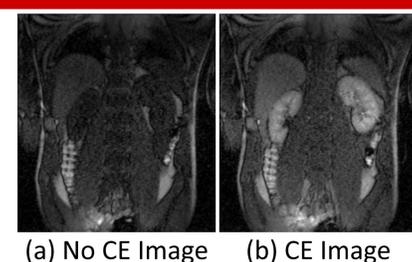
Results of style transfer with kidney DCE-MRI. The first row (a and b) shows the input images. The second row shows the results when (a) is used as the content image and (b) as the style. The third row shows results when (b) is used as the content image and (a) as the style.
